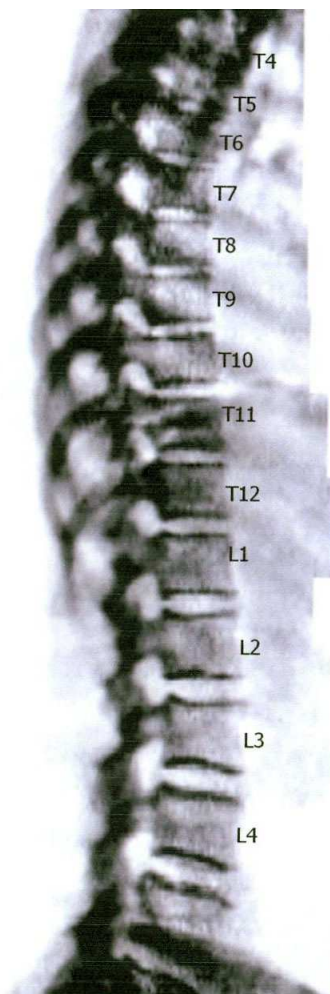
Vertebral fracture assessment from a dual x-ray absorptiometry image of the spine.
